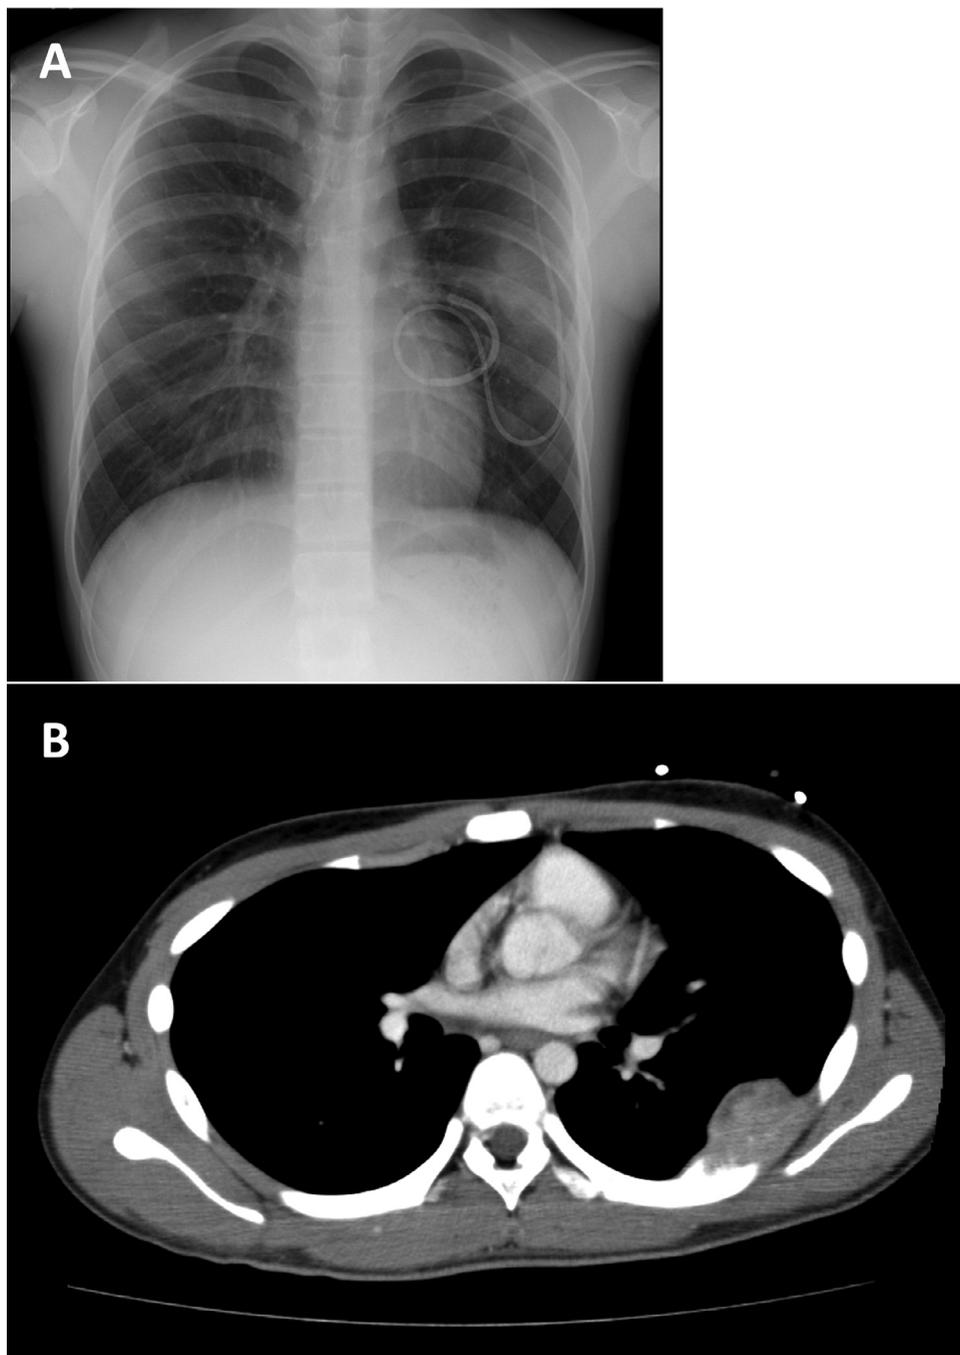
(A) X-ray image of Ewing sarcoma. The primary tumor was adhering to the left lung. (B) Computed tomography scan image corresponding to the mass in the area of reduced permeability on the left chest side in x-ray image (A).
